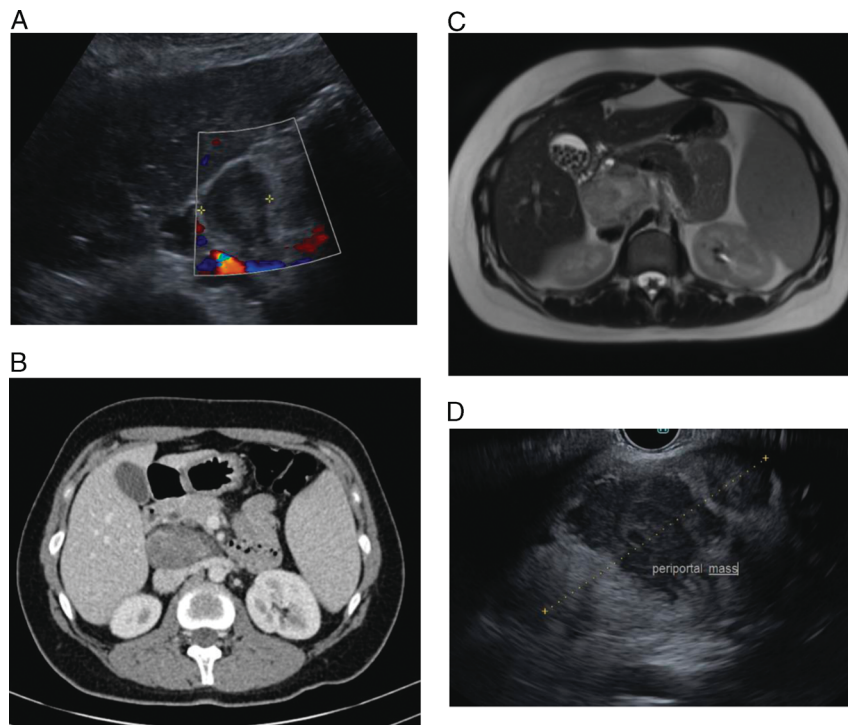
A 29-year-old woman presented with epigastric discomfort and underwent an ultrasound (A), which demonstrated a lobulated, heterogeneous lesion in the region of the porta hepatis. A subsequent computed tomography (CT) (B) demonstrated the abnormality in the retroperitoneal space, abutting the portal vein but distinct from the pancreatic gland. On T2-weighted magnetic resonance imaging scans (C), the lesion exhibited mixed signal characteristics with areas of enhancement. EUS (D) showed a periportal mass of mixed echogenicity and scattered anechoic foci. FNB confirmed the diagnosis of ganglioneuroma. FNB: fine-needle biopsy.
